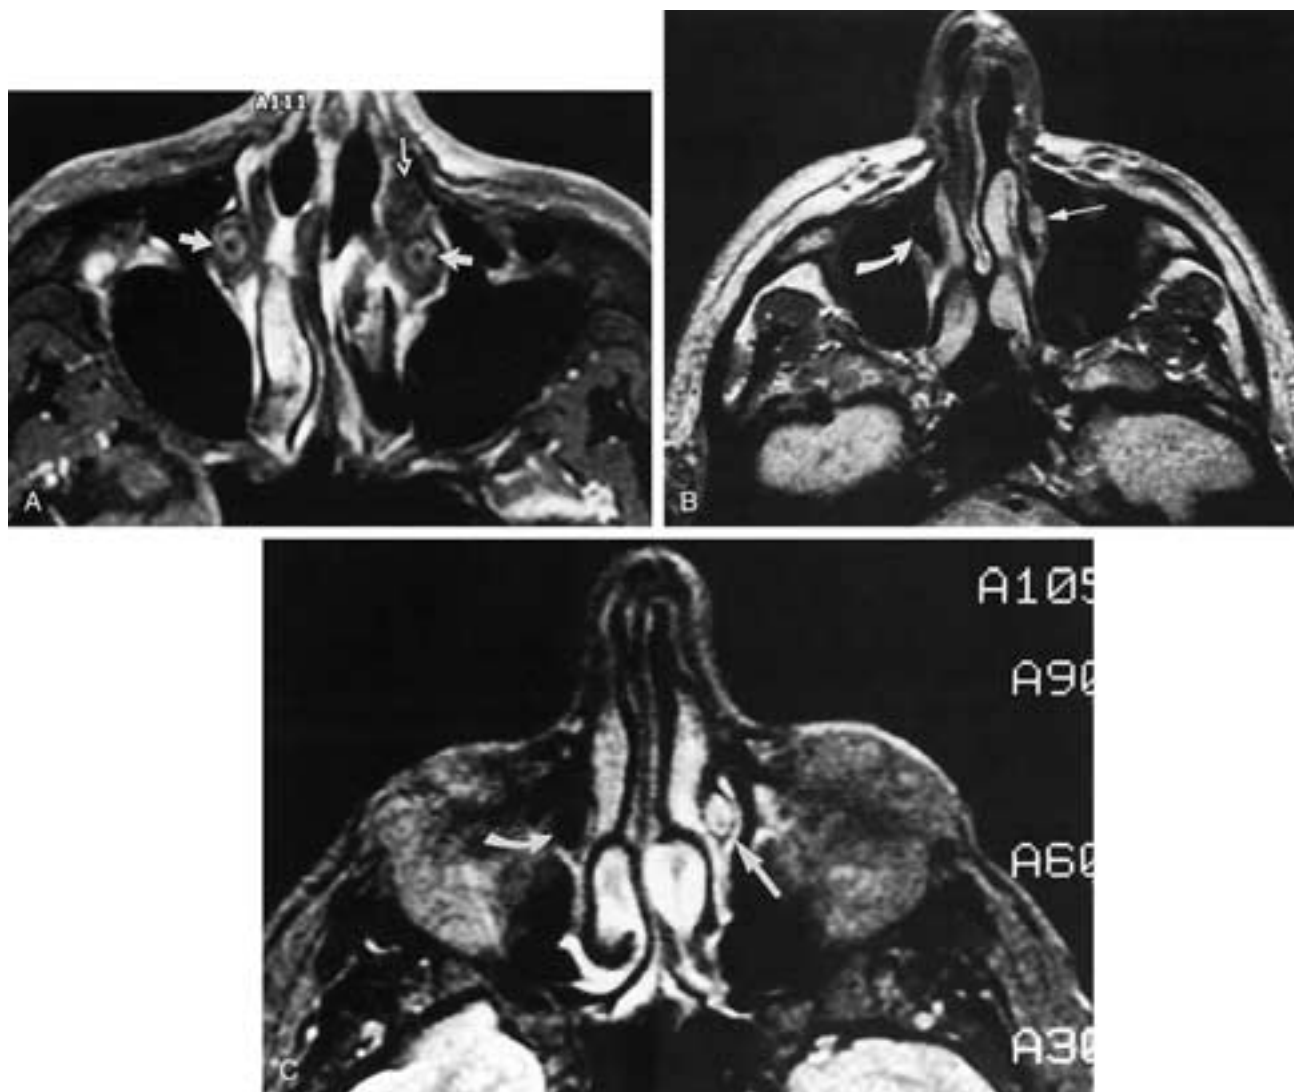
Nasolacrimal canal assessed by MR imaging. A, Patient with chronic inflammatory disease of the NLDS. Axial T1-weighted postgadolinium image shows mucosal enhancement of the nasolacrimal duct epithelium (*white arrows*). Nasal polypoid tissue is anterior to the nasolacrimal duct (*open arrow*). B and C, Another patient. B, Axial proton density image at the level of the inferior meatus shows the left nasolacrimal duct (*thin arrow*) just proximal to the valve of Hasner. Air in the right nasolacrimal canal is seen as signal void (*curved arrow*). C, Axial T2-weighted image scan shows the left nasolacrimal duct (*straight arrow*) within the canal. Air in the right nasolacrimal canal is seen as signal void (*curved arrow*). (See also [Fig. 10-25](#).)
